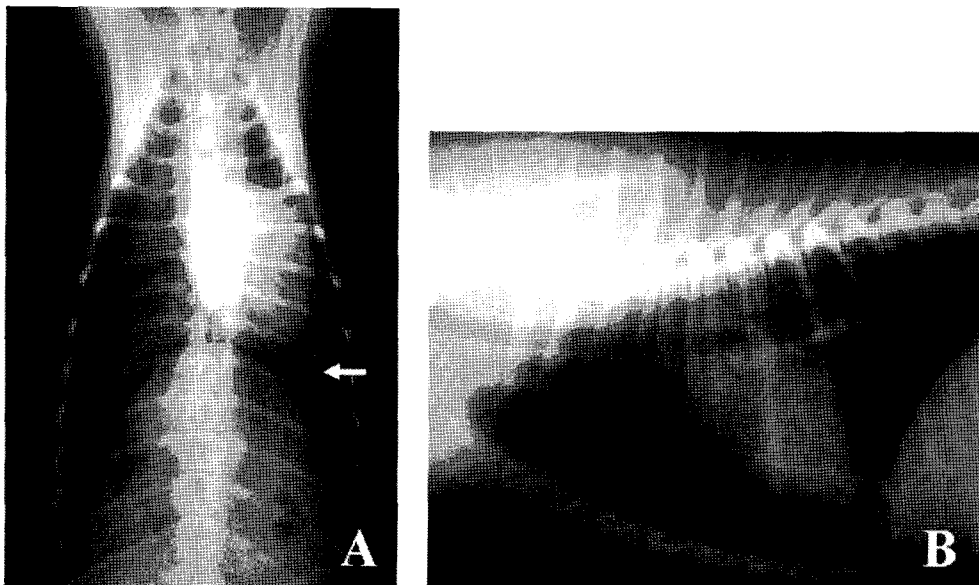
Ventrrodorsal (A) and right-lateral (B) radiographs depicting right pneumothorax. A: Right lung is collapsed and contrasted with the air-filled pleural space, and pulmonary infiltration is observed in left caudal lobe (white-delete arrow). The mediastinum, heart, and great vessels are shifted to the left. B: There is increased separation between the heart and the sternum owing to atelectasis of the dependent right lung.
